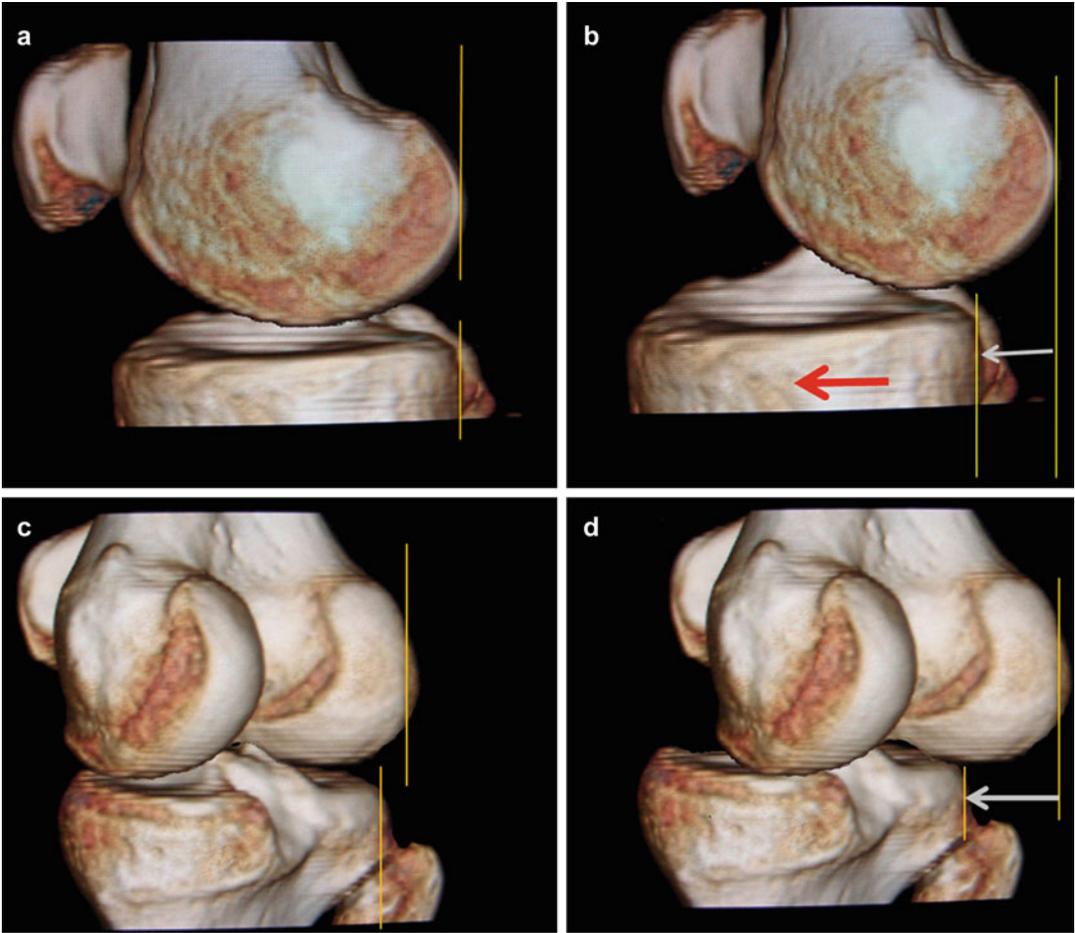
CT 3D representation of the effect of PKTD® effect on anterior translation for medial compartment (a, b) and lateral compartment (c, d)
